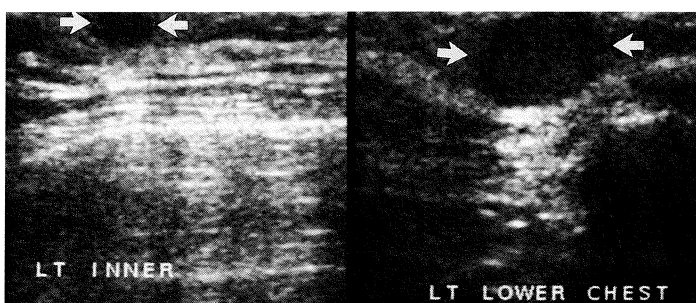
Ultrasound scans of the (A) left inner breast and (B) left lower chest wall.
